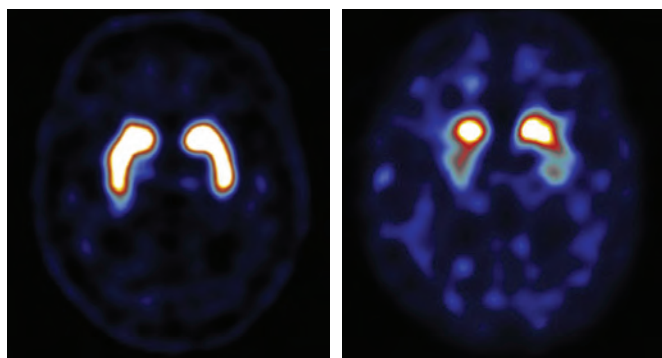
The FPCIT SPECT image on the left demonstrates normal striatal function. The image on the right demonstrates markedly reduced dopaminergic function with radioligand uptake confined to the caudate in a patient with progressive supranuclear atrophy.
